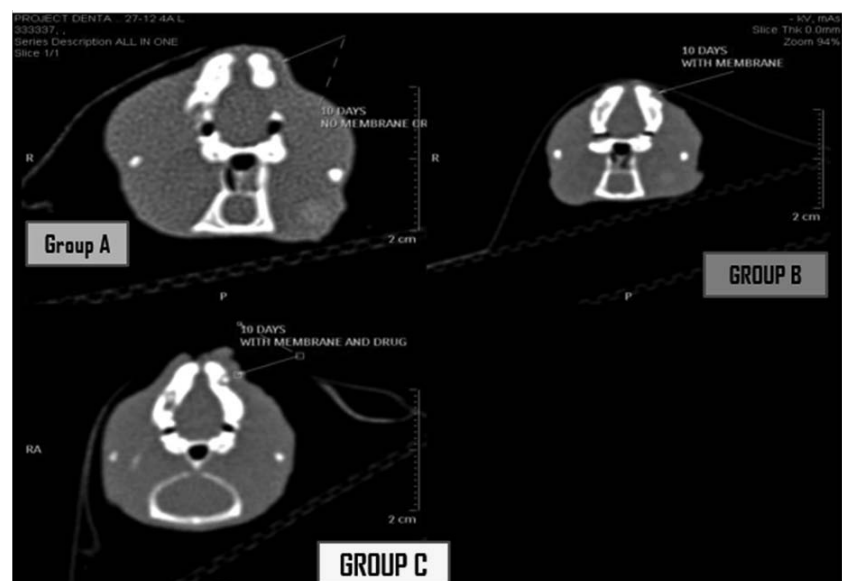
CT Image on Day 10
